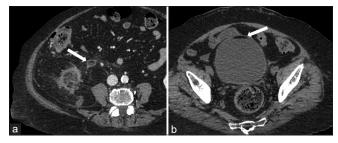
An 82-year-old female who presented with dysuria, frequency, and cloudy white urine 5 months post-cryoablation. Axial CT images showing fat-fluid levels (arrows) in the proximal ureter (a) and bladder (b).
